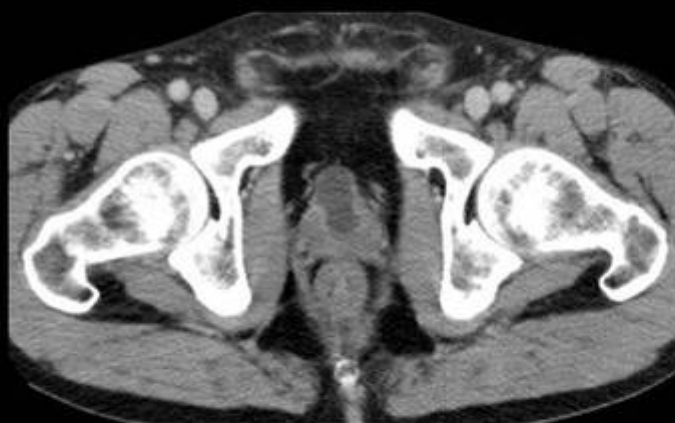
Man, 39 years old with chronic renal failure, fever and anorexia. CT urography contrast shows a small, shrunken and deformed bladder due to tuberculosis. Courtesy of Dr. Hugo Correia, HSTViseu.
